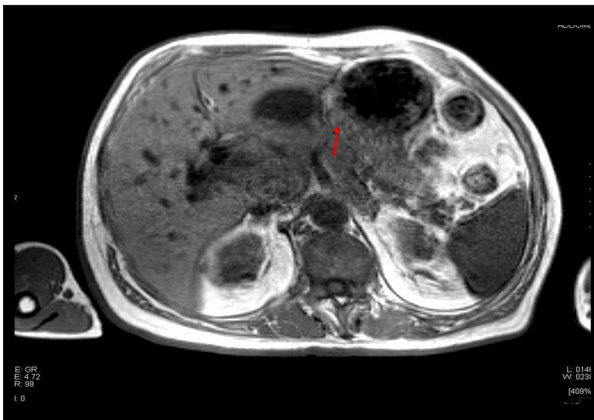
MRI: retroperitoneal, polycyclic, and inhomogeneous mass, defined as “likely attributable to lymphoma”. The arrow indicates the main lymph node aggregates.
